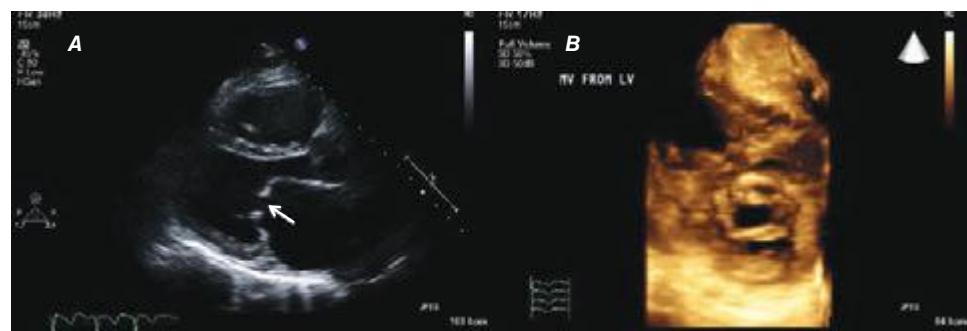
24 A. Rheumatic mitral stenosis showing pliable leaflets tethered at the tips (arrow). Note the characteristically enlarged left atrium. B. Mitral stenosis visualized from a three-dimensional echocardiogram.
